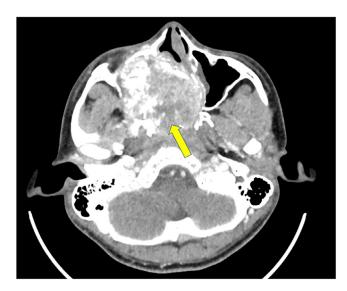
Head CT scan of the third patient. A hypervascular mass in the right nasal cavity region, superiorly obliterating the right sphenoidal sinus, laterally obliterating the right maxillary sinus, medially eroding and pushing the nasal septum to the left (yellow arrow).
